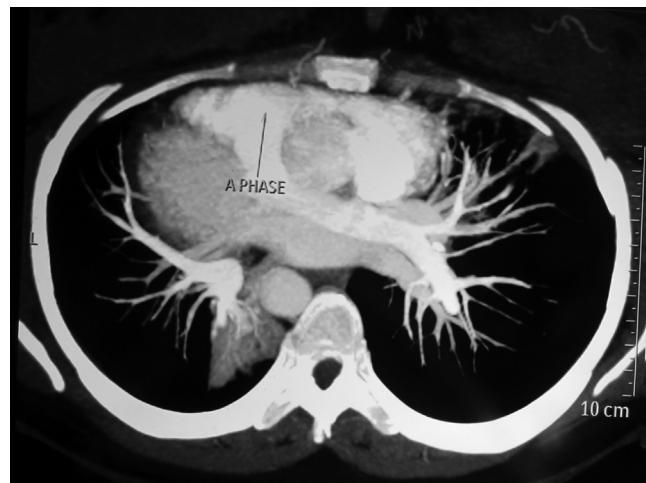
Contrast enhanced CT scan of thorax (axial view) showing pulmonary artery and veins.
